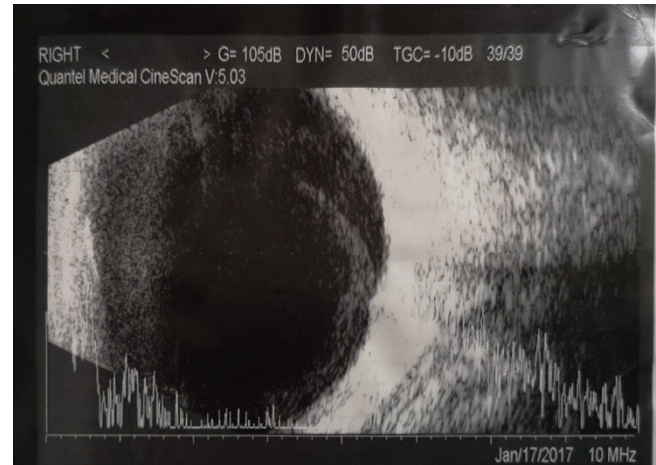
Case 1: Ultrasound B scan showed vitreous opacities and loculations at the superior vitreous
